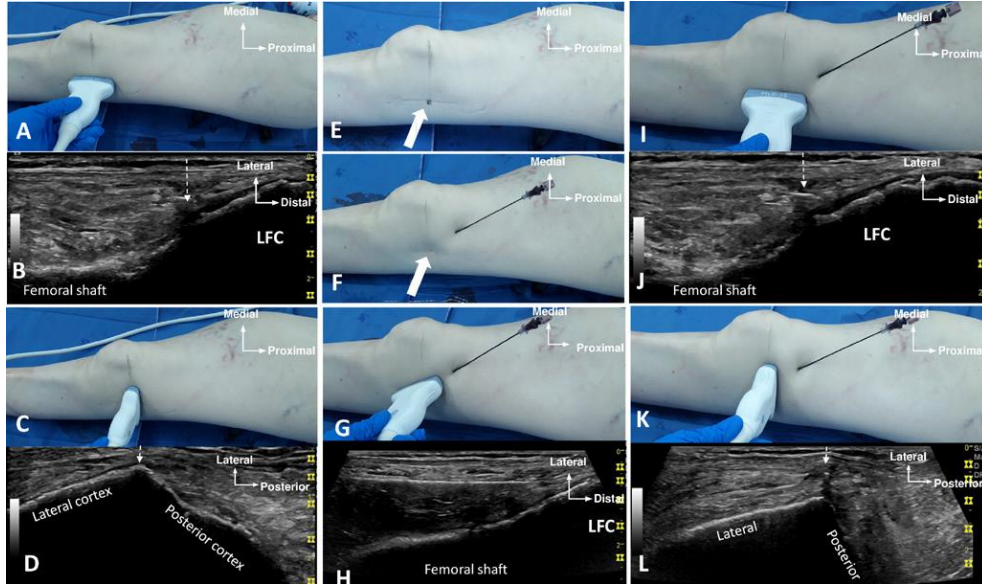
Cannula placement and ultrasound landmarks for SLGN in cadaveric knee. (A, B) coronal plane: target point for SLGN and transversal skin mark. (C, D) Axial plane: target point for SLGN. (E) Target Skin point. (F): 45° cannula introduction. (G, H) oblique in-plane insertion of cannula. (I, J) Coronal plane: final position of the cannula tip. (K, L) Axial plane: final position of the cannula tip. Vertical dashed arrows indicates the US target point. SLGN, superior lateral genicular nerve; LFC, lateral femoral condyle; US, ultrasound.
